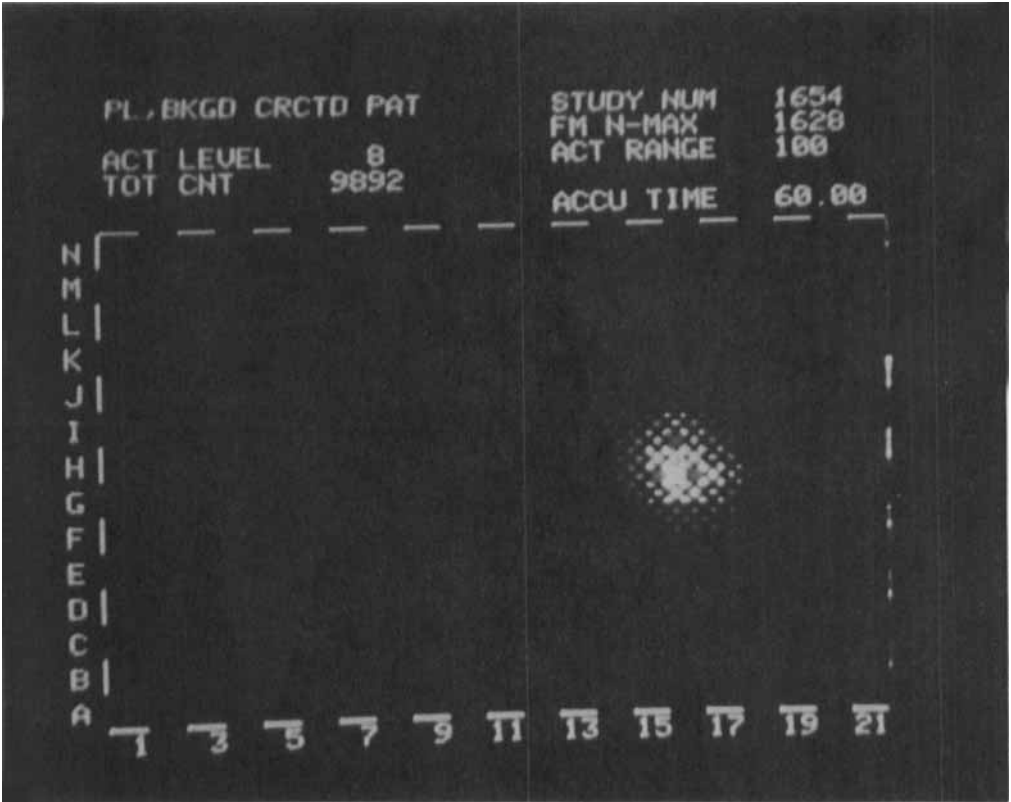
Monitor screen of scintigraphy apparatus showing one dosage form (non-disintegrated).
